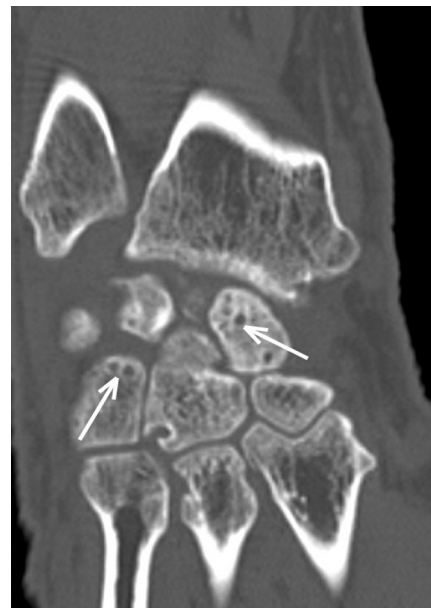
Coronal CT slice of the left wrist: multiple cysts in several carpal bones (arrows) and calcifications in the scapholunate space.
